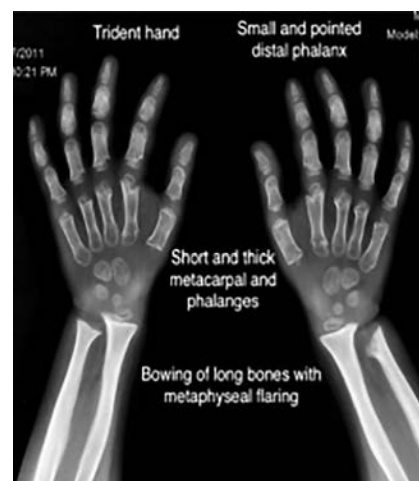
Findings in achondroplasia on hand radiograph
